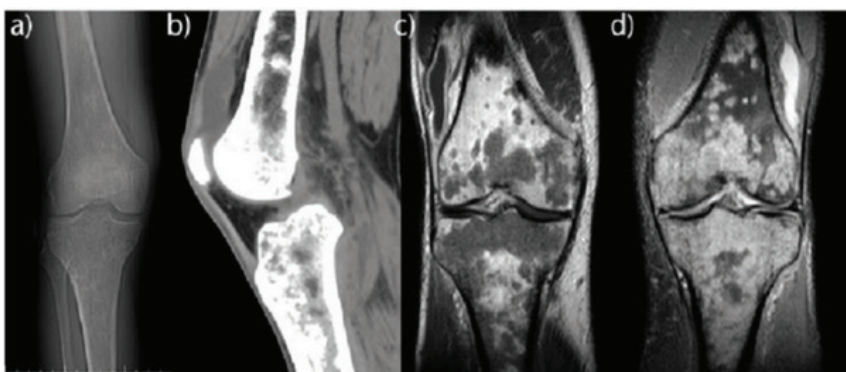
a) frontal knee X-ray shows heterogeneous marrow density in the distal femur and proximal tibia. b) CT sagittal reformat exhibits the sclerotic bone infiltration. c) T1 weighted coronal MRI knee post contrast highlights the extent of abnormal marrow signal. d) T2 fat saturated coronal MRI knee also demonstrates the magnitude of bone infiltration in a patient with Erdheim Chester disease (non-Langerhans cell, non familial, multisystem histiocytosis).
